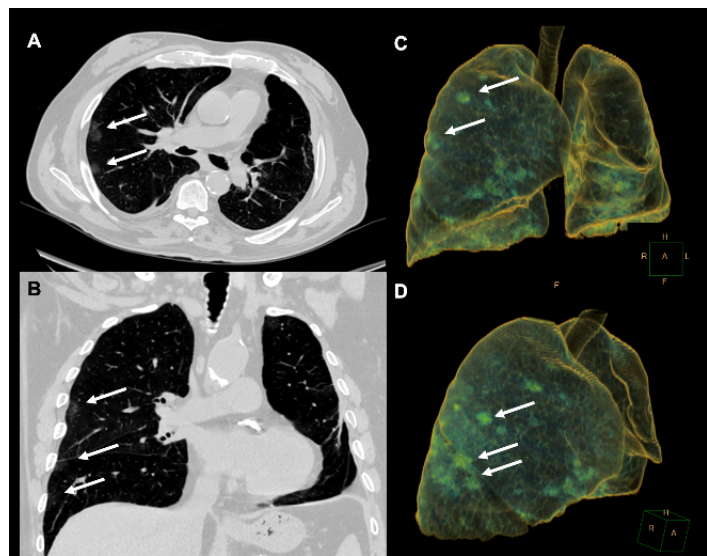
Case 1: 76-year old male was admitted to the Emergency Department due to fever and dyspnea for few days. RT-PCR diagnosed COVID-19 infection. Axial (A) and coronal (B) non-contrast-CT images and corresponding volume rendered three-dimensional CT of the lungs (C, D) showed few peripheral ground glass opacities (arrows) within the lower and middle lobes of the right lung.
